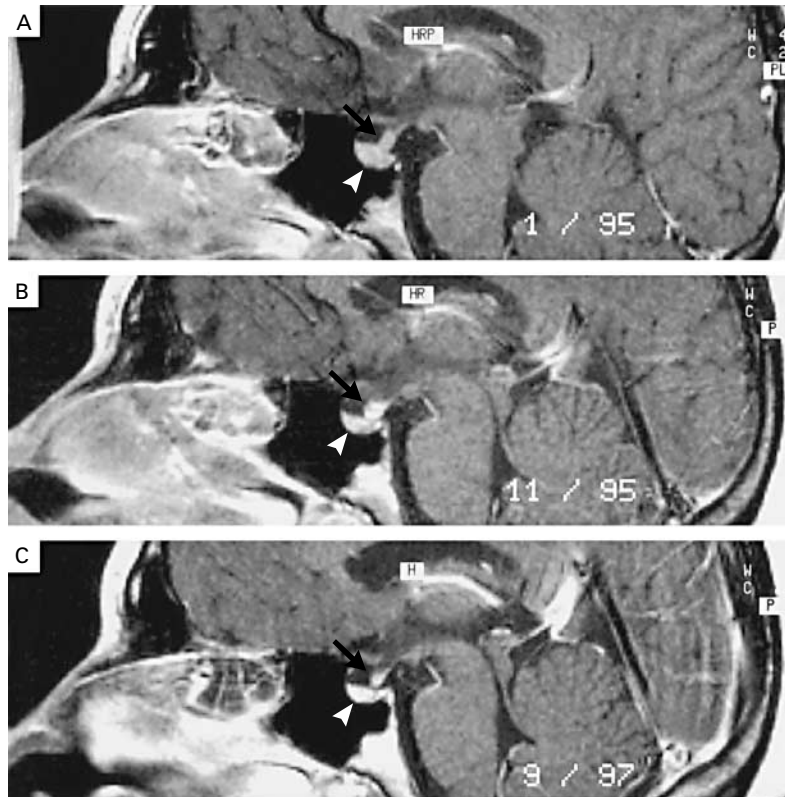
Sagittal T₁-Weighted MRI Scans with Gadolinium Enhancement Obtained in a Patient with Central Diabetes Insipidus Caused by Langerhans'-Cell Histiocytosis.
